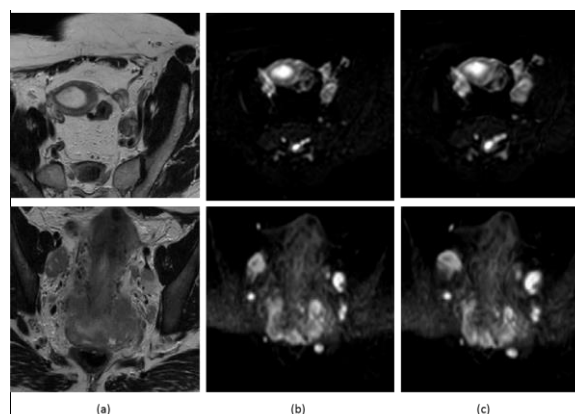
Examples of our registration results. Two types of MRI images (T2-w axial and DW Image) are used. (a) Fixed image is: Axial T2-w image, (b) Moving image is: DW image, and (c) registered image.
